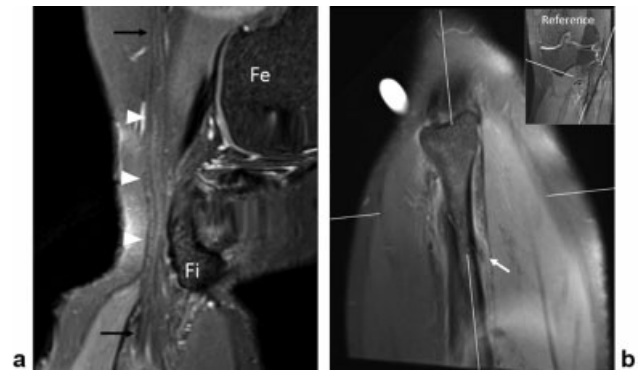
(a) For a patient with peroneal nerve symptoms after an injury, the entire course of the common peroneal nerve is visualized on a single image with a curved multiplanar reconstruction (MPR) using a three-dimensional fast spin-echo sequence acquired as part of a standard knee protocol, demonstrating segmental nerve fascicle enlargement and increased signal (white arrowheads) proximal to the fibula relative to the normal signal and caliber of the more proximal and distal portion of the nerve (black arrows), consistent with neuritis. (b) The subacute healing nondisplaced proximal fibular fracture (white arrow) is also well depicted on a thick nonorthogonal MPR along the long axis of the fibula, oblique to the routine sagittal plane; the fracture was occult on radiographs at the time of the trauma. A reference image (top right corner) is provided to demonstrate the referenced nonorthogonal planes used to create an optimized MPR. Fe, femur; Fi, fibula.
